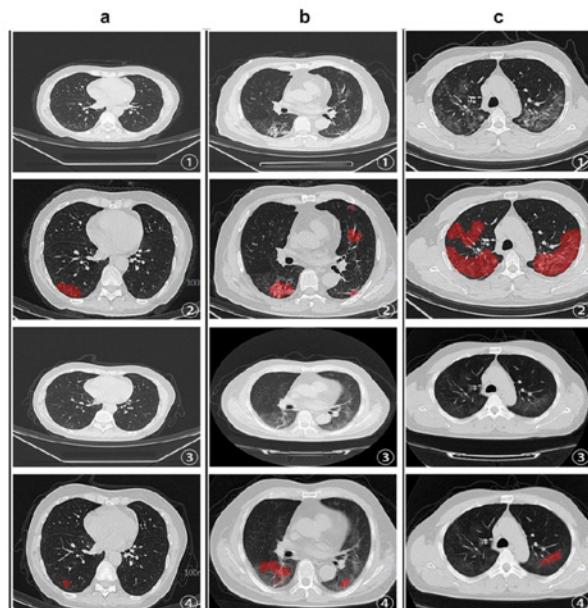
shows comparison of chest HRCT results between patients at discharge and 30 days after hospital discharge. a, b and c represent three separate patients:
